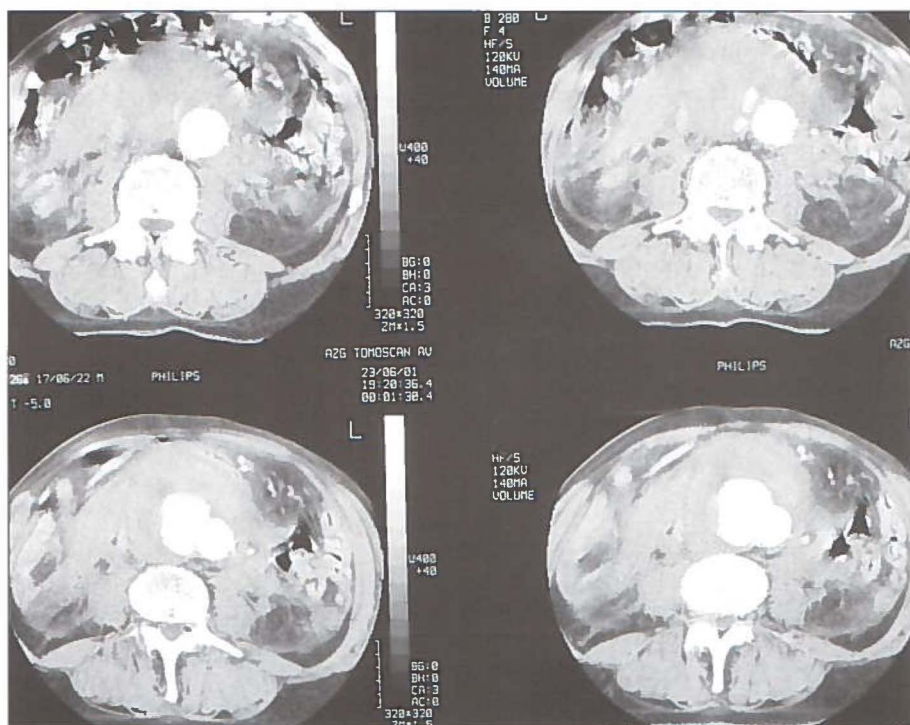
Pre-operative CT scan showing a ruptured abdominal aortic aneurysm with a large retroperitoneal hematoma
